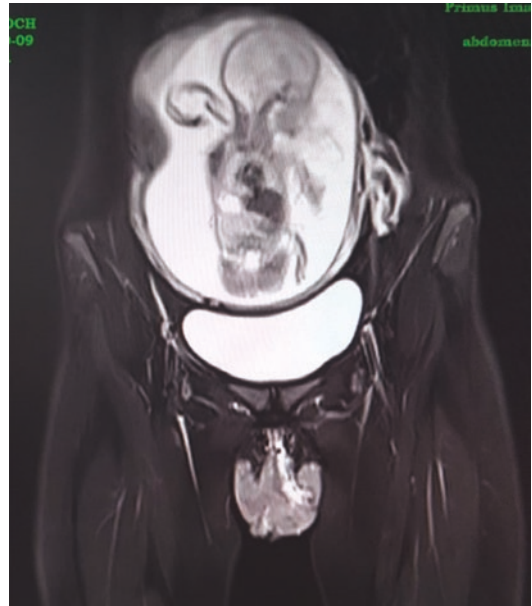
MRI image showing vulvar growth with pregnancy
